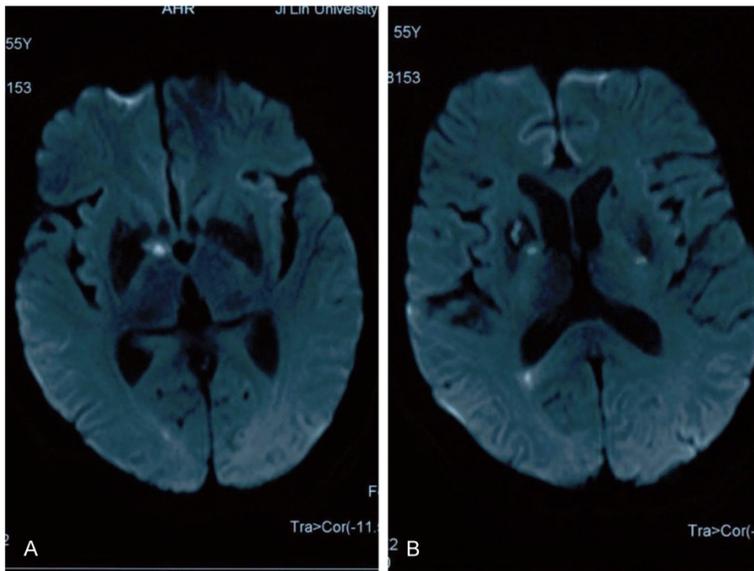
MRI images. (A and B) DWI images showed multiple infarcts at different times in the bilateral thalamus.
